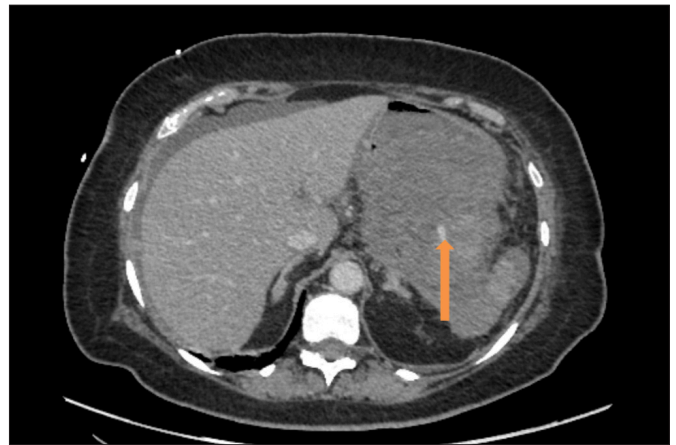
CT scan showing large haematoma and inflammatory mass with active bleeding (indicated by arrow).
